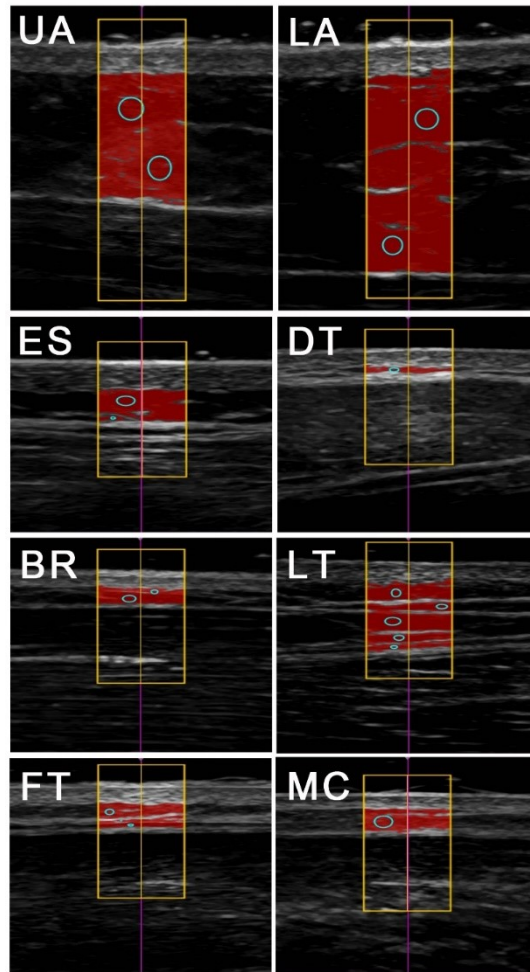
B-mode ultrasound measurement of uncompressed subcutaneous fat
